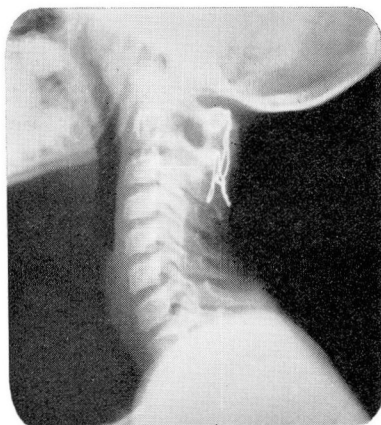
Roentgenogram of lateral cervical spine showing solid spinal fusion extending from the first to the third cervical vertebrae with posterior bone graft and wire fixation.
